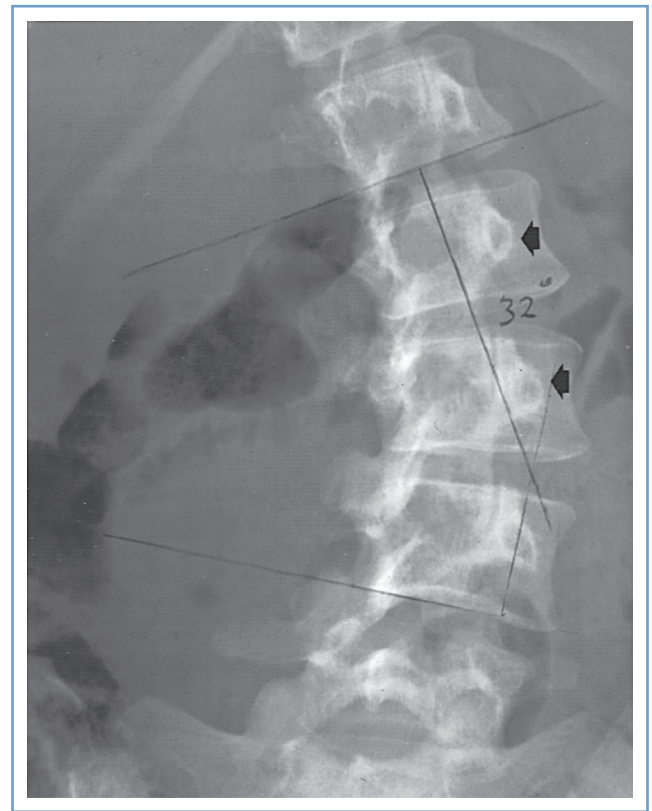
■ Radiographic study of the lumbar spine in a 26-year-old woman with idiopathic scoliosis. The spinous processes and pedicles (arrows) are rotated away from the convexity and into the concavity of the curve. (The epidural space was entered easily with direction of the needle approximately 15 degrees off the perpendicular at the skin level toward the convexity of the curve.)
